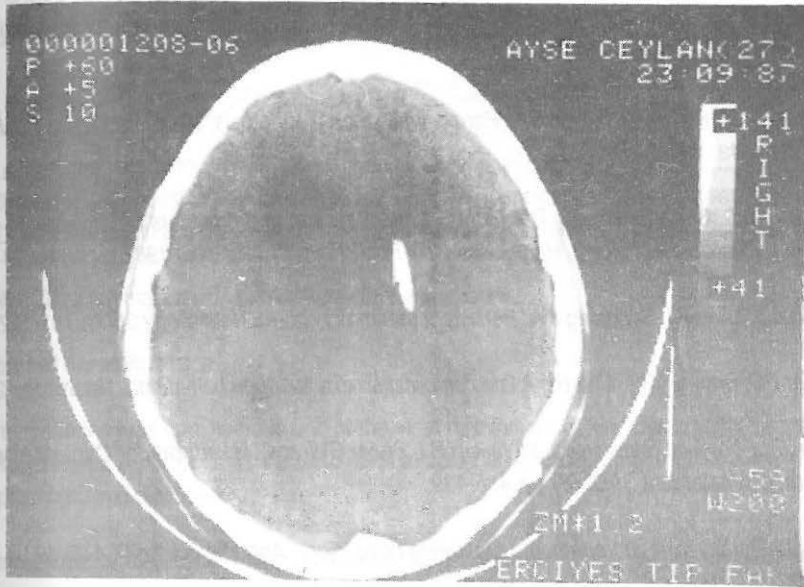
CT scan three weeks after ventriculo peritoneal shunting
